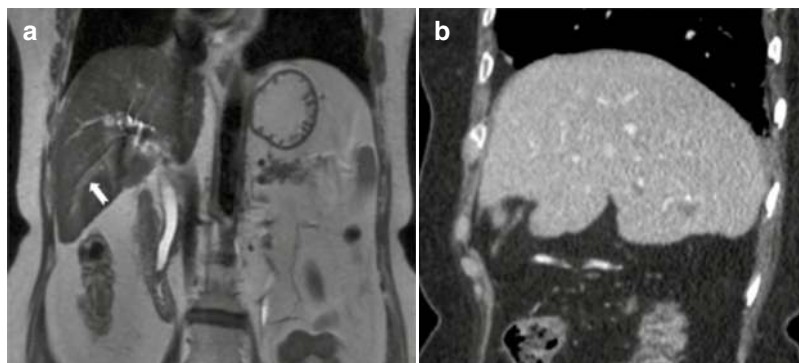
Imaging findings in biopsy-proven cases of primary biliary cholangitis. (a): Periportal hyperintensity (white block arrow) is seen in T2-weighted sequences suggestive of periportal inflammation. (b): A different
